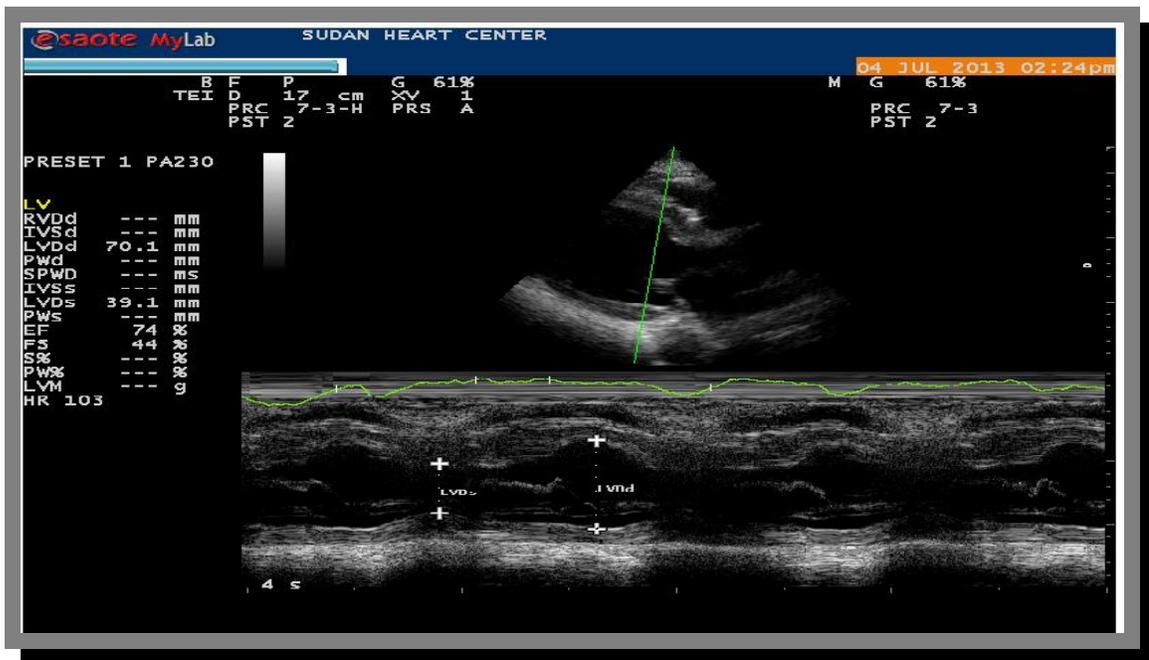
M-mode echocardiogram showing the LV diastolic and the systolic measurement and EF all of which are normal.
